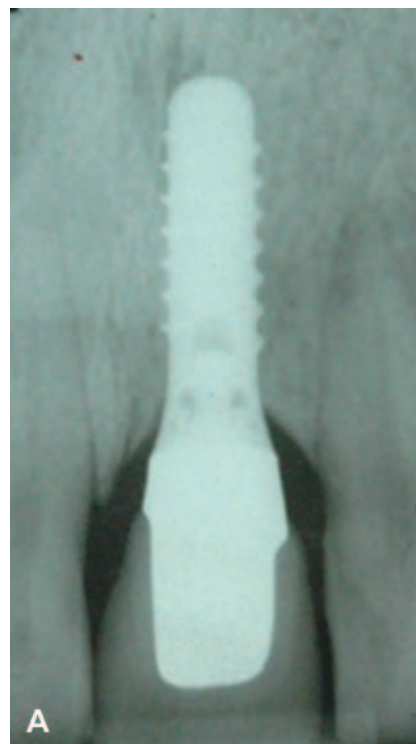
An intraoral dental radiograph (A) and a color slide (B) of the same area.
